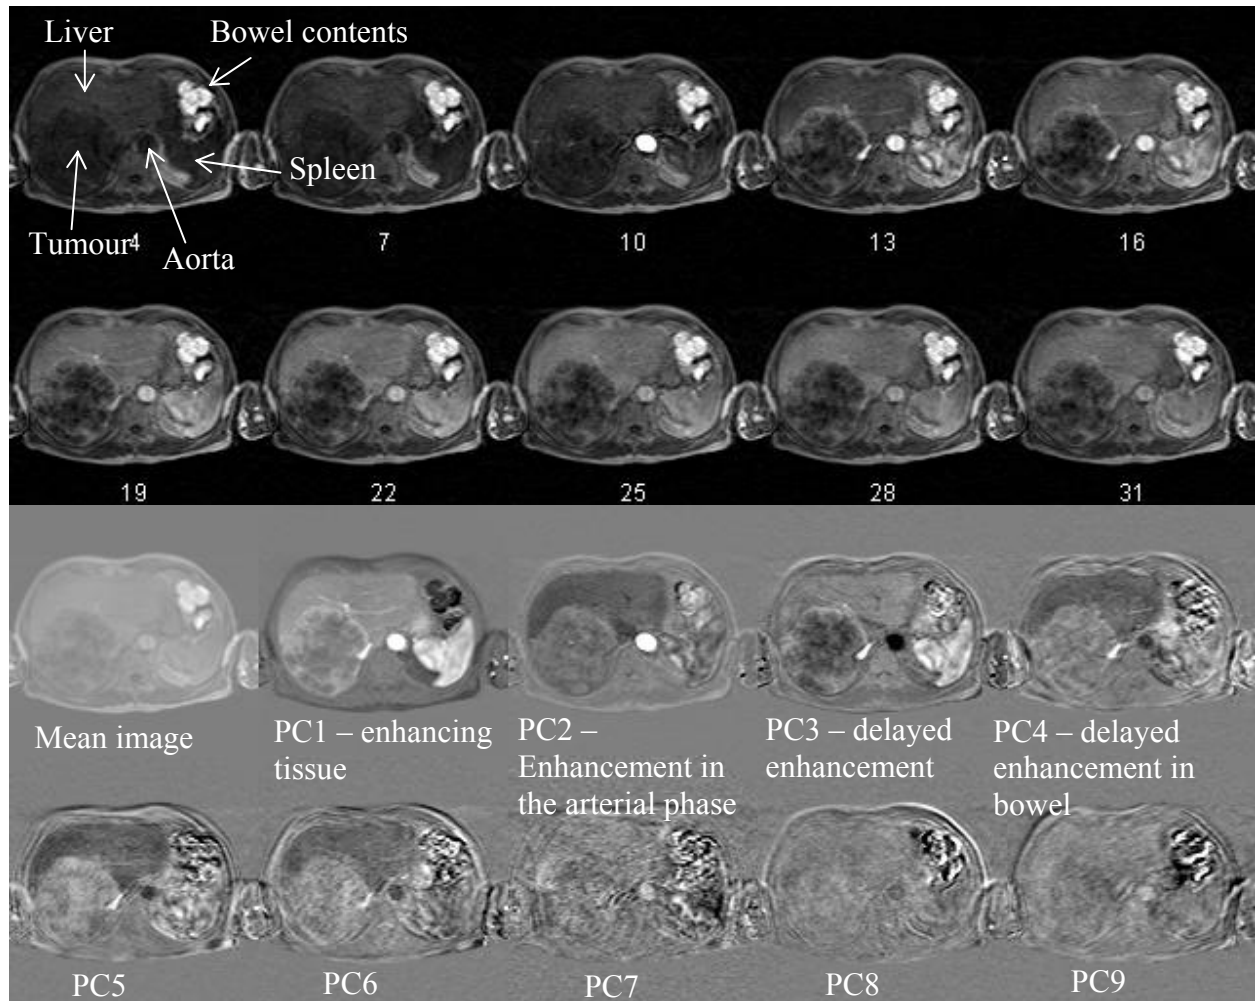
PCA analysis in a DCE-MRI time series in a liver tumour. Top: time series showing signal change due to arrival of contrast agent (number indicate image index). Bottom; Mean time series image plus first 9 principal component (PC) eigenimages. The approximate physical interpretation is given, where appropriate.
